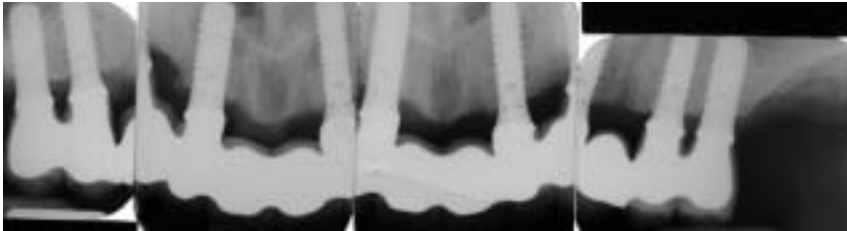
Radiographs of final restoration
